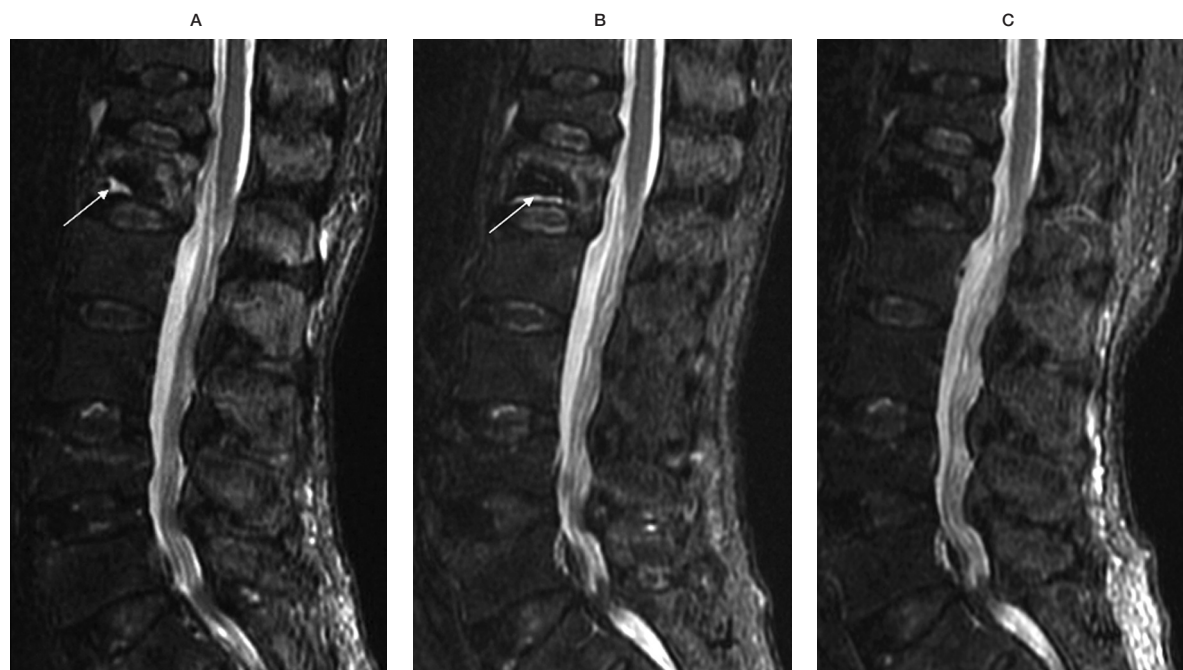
(A) A 78-year-old woman had severe back pain after falling down. This STIR image showed a L1 compression fracture with bone marrow edema and a vacuum cleft (white arrow). After the initial percutaneous vertebroplasty (PV), the woman had significant pain relief on the day 1 postoperative follow-up and returned home. (B) About 1 month after the initial PV, the patient had severe recurrent back pain. The follow-up STIR image showed persistent bone marrow edema and a small amount of fluid collection (white arrow) in the interface between the cement and residual bone. (C) After repeat PV, the 3 month follow-up MRI showed resolution of the bone marrow edema in the residual bone. There was no fluid collection in the interface between the cement and residual bone. The patient had significant pain relief and improvement of mobility (pain score, 10→0; mobility score, 4→0).
